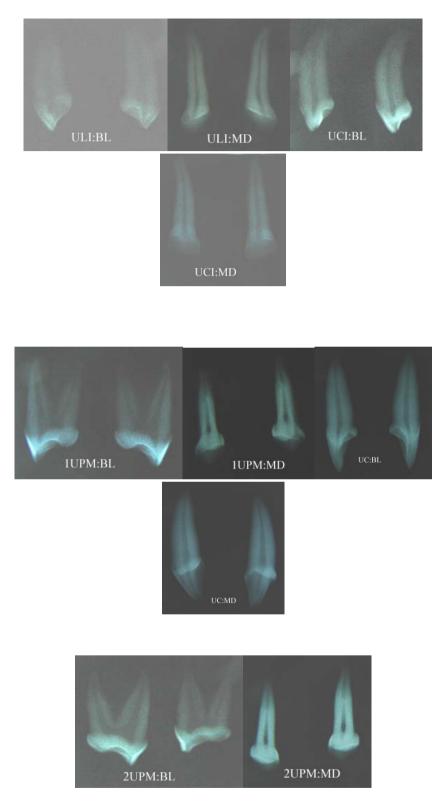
Periapical radiograph of maxillary teeth (Linnaeus, 1758).
